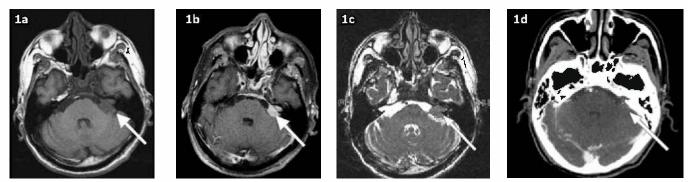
T1-w axial MR image (a) without contrast; (b) with contrast; and (c) T2-w axial MR image show a left-sided cerebellopontine angle mass (17 mm x 16 mm) extending into the left internal auditory meatus (arrows). Diffuse non-specific dural enhancement is also noted posterior to the clivus. (d) CT image at the time of initial diagnosis of nasopharyngeal carcinoma shows no obvious mass at CPA (arrow).
